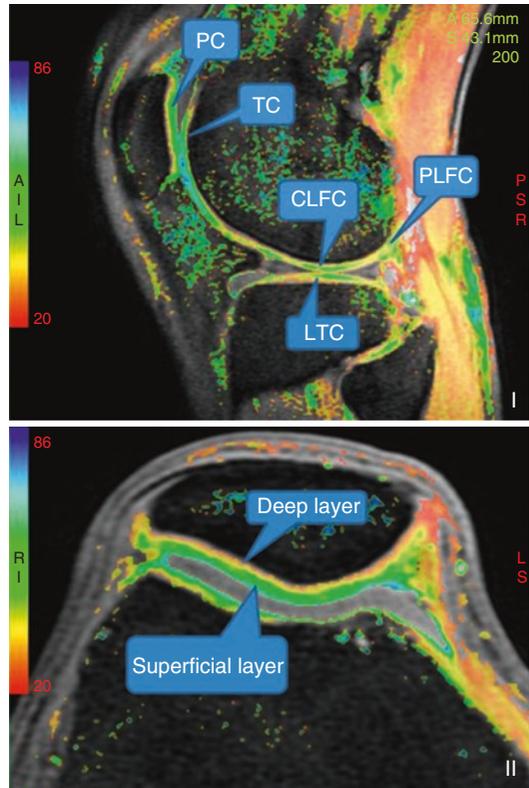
T1 Rho Imaging of Knee Cartilage [35]: (I) sagittal and (II) axial views. Scales on the left with blue indicating healthy cartilage and red indicating decreased proteoglycan content (signaling worn cartilage). PC patella cartilage, TC trochlear cartilage, CLFC central lateral femoral condyle, LTC lateral tibial cartilage, PLFC posterior lateral femoral cartilage. Obtained from Chen M, Qiu L, Shen S, et al. The influences of walking, running, and stair activity on knee articular cartilage: Quantitative MRI using T1 rho and T2 mapping. *PLoS One*. 2017;12(11):e0187008
